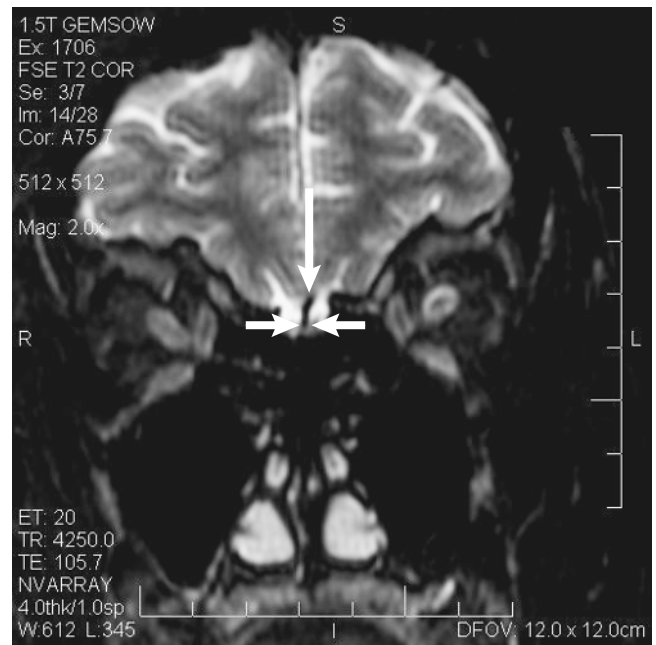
Magnetic resonance imaging (MRI) view of the olfactory nerves (short arrows) on either side of the crista galli. (long arrow).
